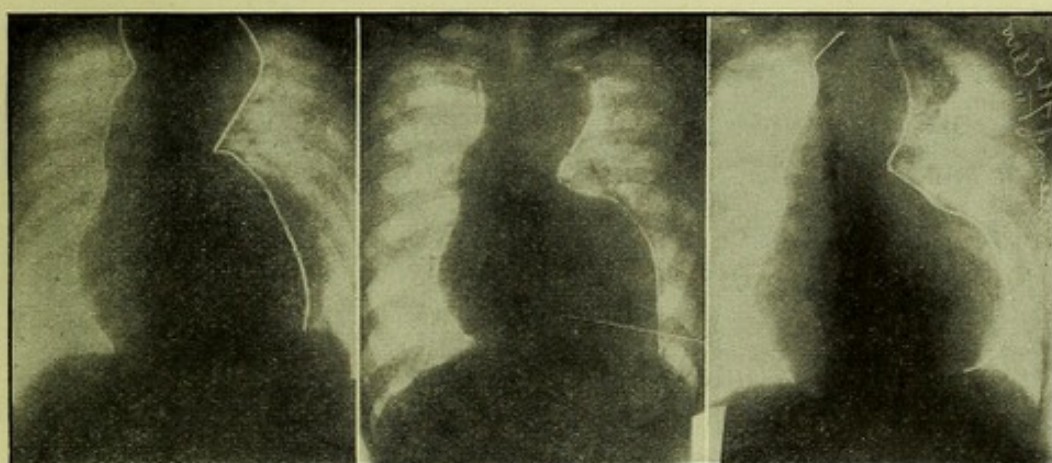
Skiagraphs of an aneurysm treated by Dr. George Jarvis of Philadelphia. Also show the areas of heart and aneurysm, as determined by percussion with corroboration of the latter by the X-ray findings. A, skiagraph before concussion of the 7th cervical spine; B, diminished area after concussion; C, from same patient symptomatically cured after treatment for one month.
